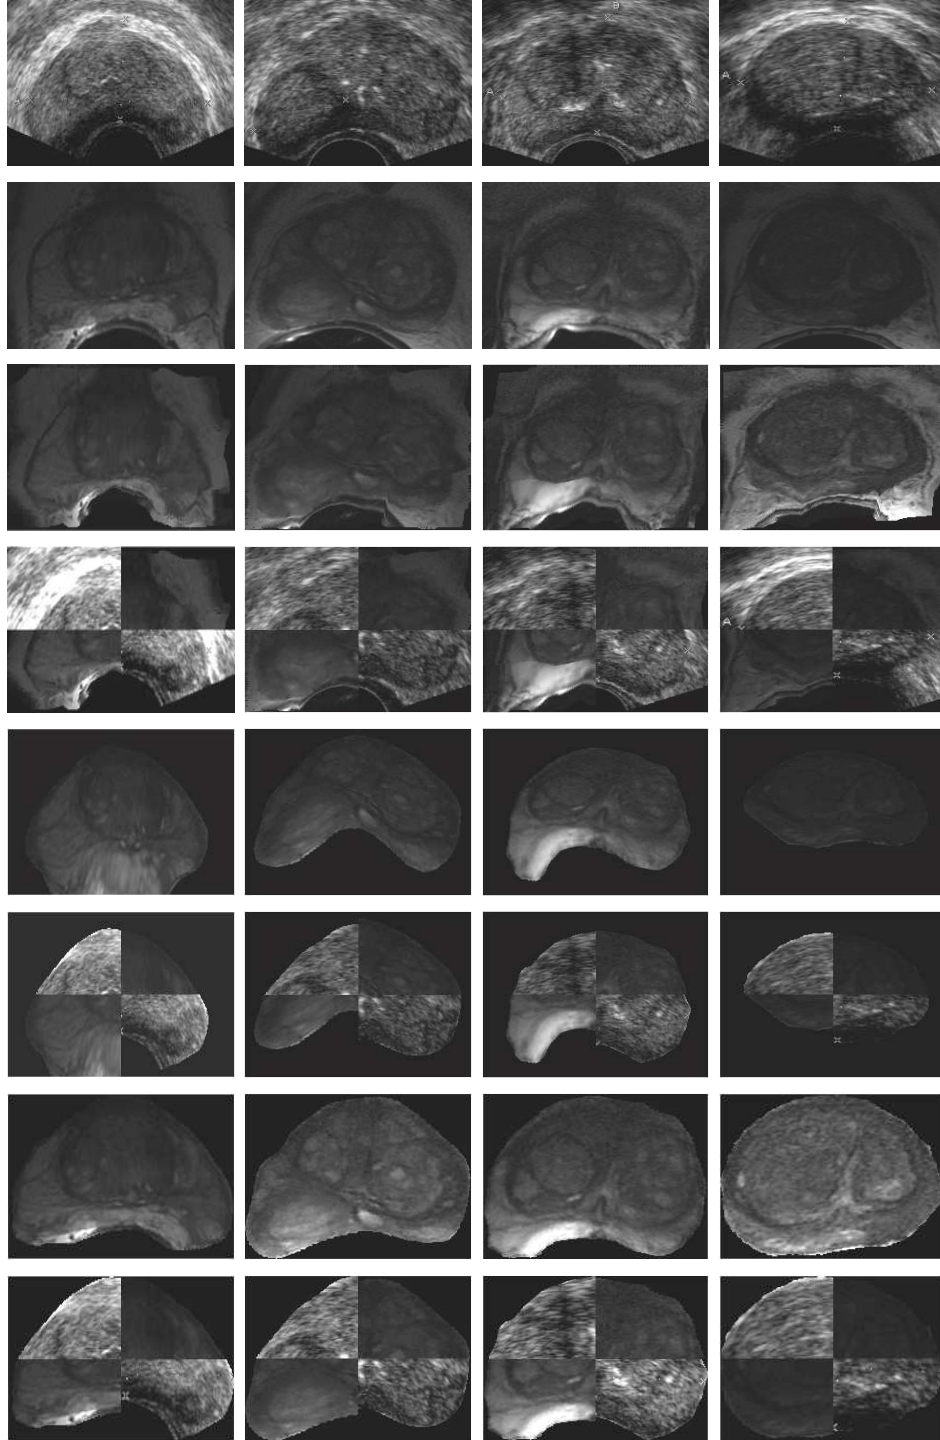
Qualitative registration results for TPS, B-splines compared with the proposed method (NLTPS-REGCORR). The columns signify patient cases 1, 5, 15 and 17 respectively. Rows 1 and 2 show the fixed TRUS and moving MR images respectively. Rows 3 and 4 show the transformed MR and checkerboard using traditional TPS. Similarly, rows 5 and 6 show the results of B-splines and rows 7 and 8 show the results of the proposed method.
